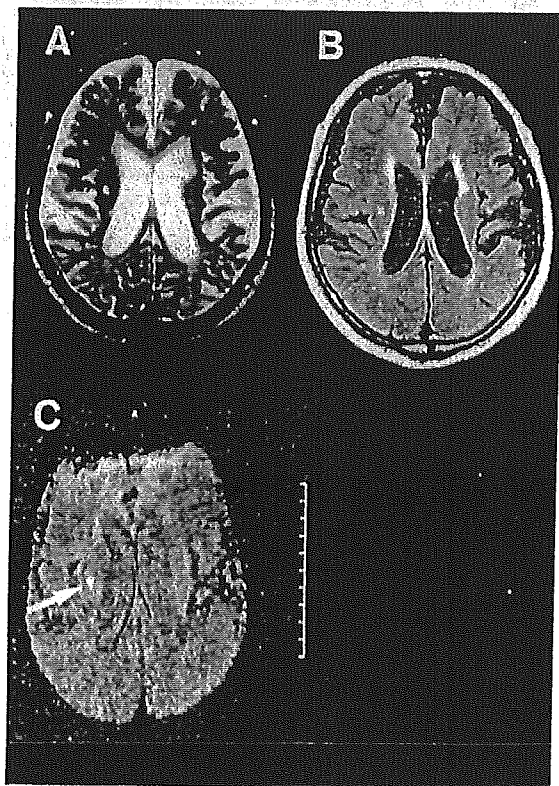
Brain magnetic resonance (MR) imaging 1 month after the episode revealed multiple cerebral infarcts. (A) T2-weighted imaging; (B) flair imaging. Diffusion MR imaging revealed a new infarct corresponding to a neurologic deficit (C, arrow) in this patient.
